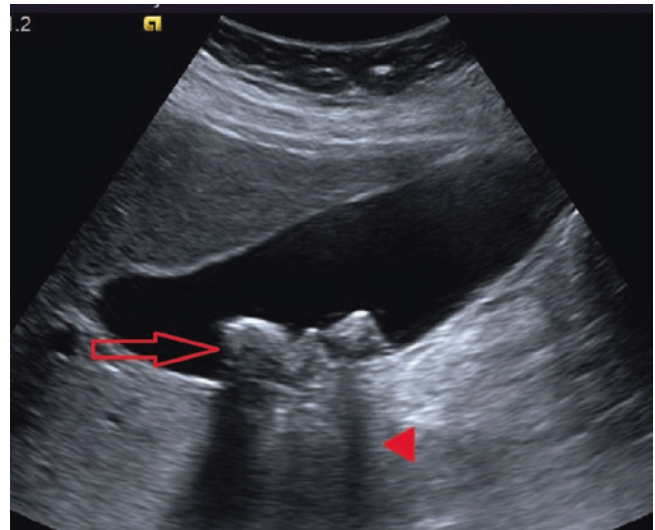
Abdominal ultrasound documenting cholelithiasis. Note the hyperechoic stones (arrow) and posterior acoustic shadowing (arrowhead)
